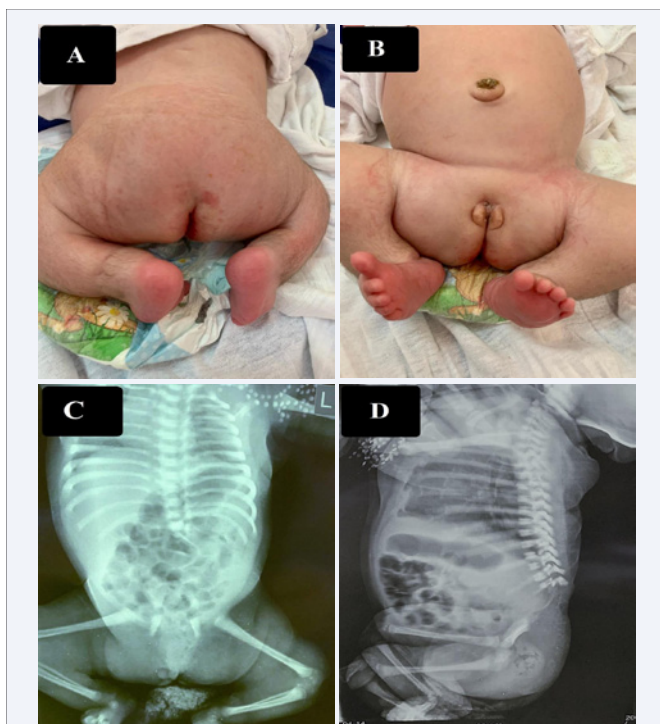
A, B, C and D: A&B; a flat buttock, bilateral knee flexion contractures, and bilateral congenital talipes equinovarus deformity. C&D; Anteroposterior and lateral plain roentgenograms of the whole spine revealed abrupt termination of the spinal column the L1 vertebral level, total sacral agenesis (Renshaw type 3), with the image of hip dysplasia by the shallow socket (acetabulum), and by displacement of the ball (femoral head) from the socket.
